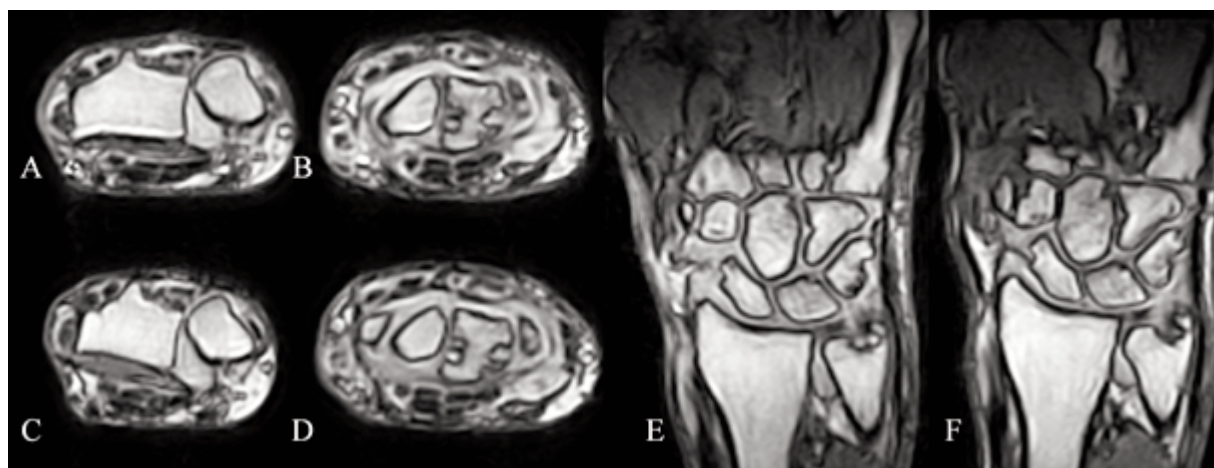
MRI of the wrist at baseline (A, B, E) and 4 weeks after IA injection of steroid (C, D, F). All images are postgadolinium. Note the synovitis score and visible erosions are unchanged. A, C: axial 3D Turbo T1 gradient-echo image of the radioulnar joint. B, D: axial 3D Turbo T1 gradient-echo image of the intercarpal joint. E, F: coronal 3D Turbo T1 gradient-echo image of the wrist.
